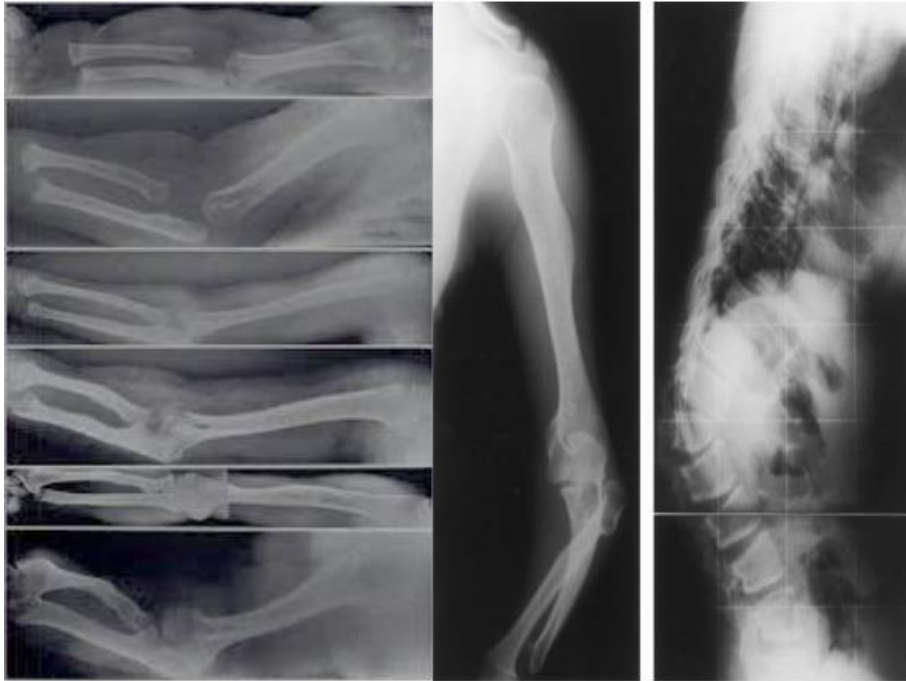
Shows some x-ray of AMD
